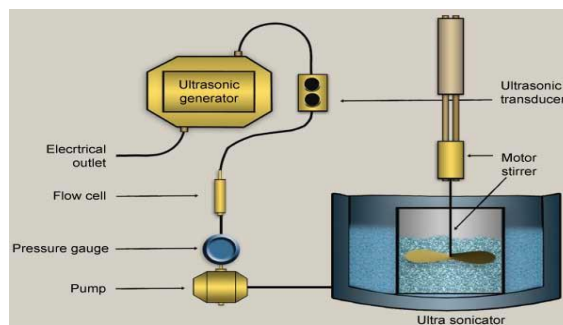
Emulsification by ultrasonic technology Screening of formulations on the basis of thermodynamic stability studies
